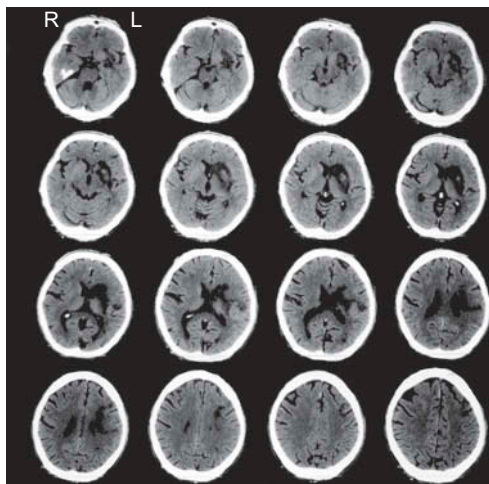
CT scan, carried out a week after the stroke, showed ischemic lesions in the left basal ganglia, extending into periventricular and supraventricular white matter, with hemorrhagic transformation within the area of lentiform nucleus, but with relative sparing of the cortical gray matter. Sides are positioned according to medical imaging convention; the left side of the brain is on the right image side.
